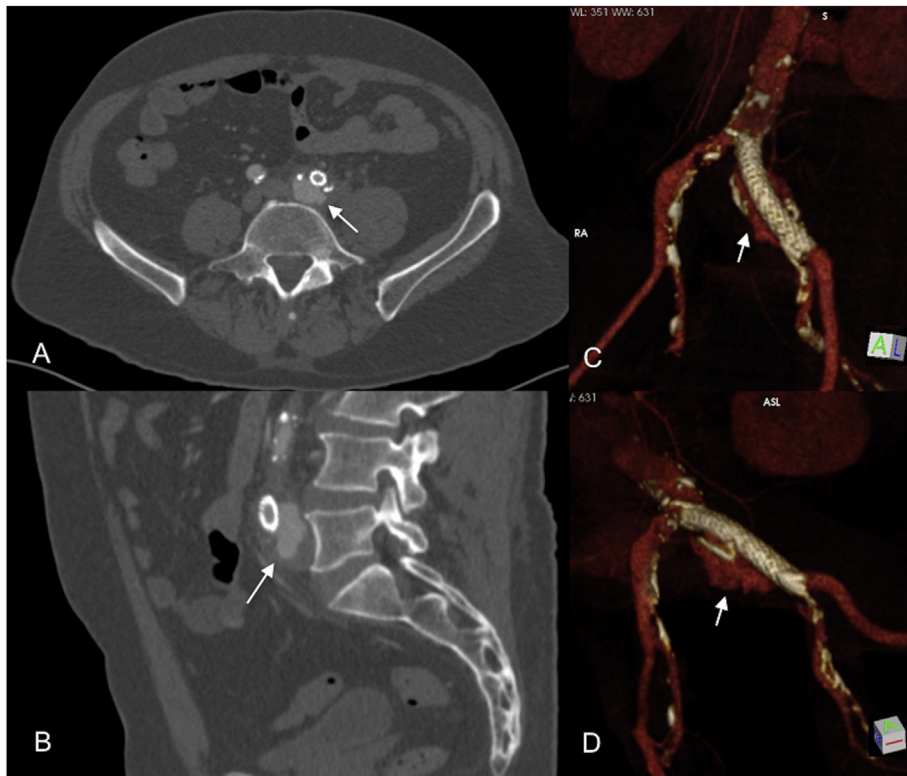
Computed tomography angiography showing the left common iliac artery pseudoaneurysm related to the stent implantation site (white arrow); axial and sagittal views (A, B); three dimensional volume rendered reconstruction of the computed tomography angiogram (C, D).
